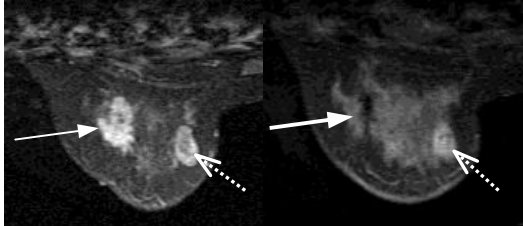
Breast MR images acquired during a wire localization procedure. The cancer (solid arrow) vanished quickly, while the fibroadenoma (dashed arrow) persisted.
